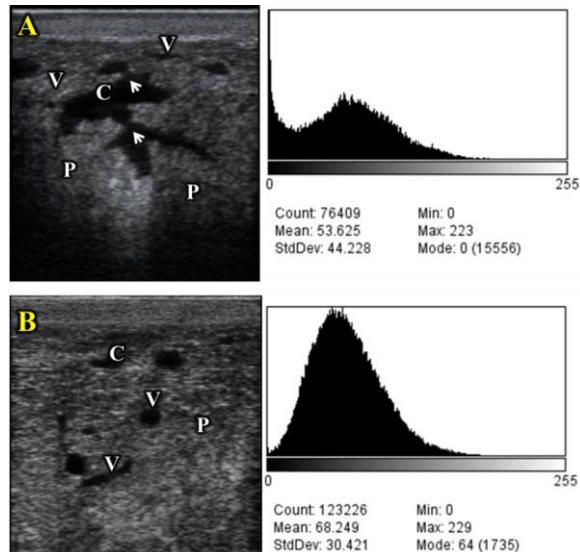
Ultrasonographic examination of buffalo mammary gland and its corresponding gray scale histogram analysis; in normal (A) and in subclinical mastitis (B). Showing the gland parenchyma (P), gland cistern (C) lactiferous duct (arrow) and blood vessels (V)
